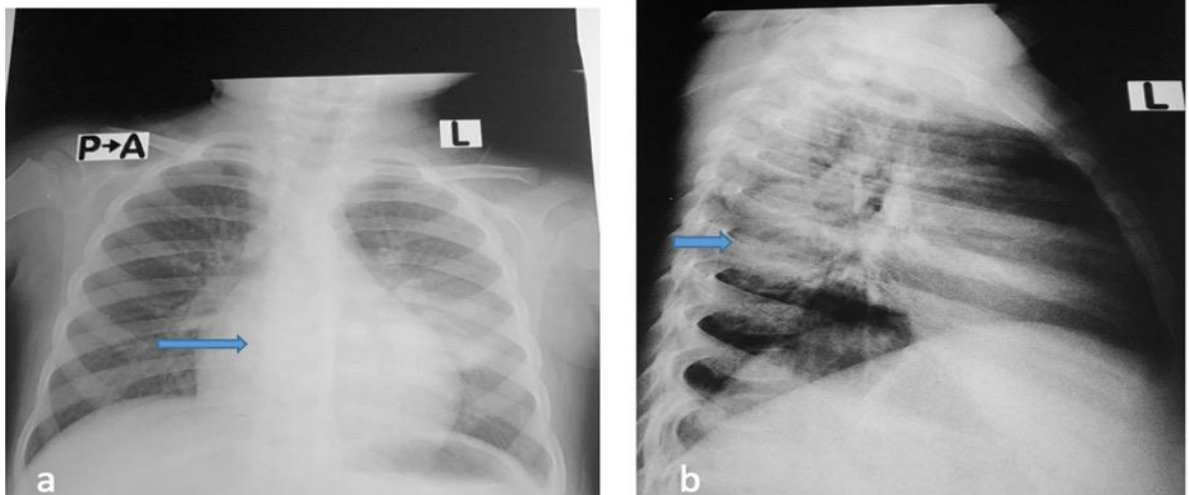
Chest radiographs (Postero-anterior [PA] and Lateral)
